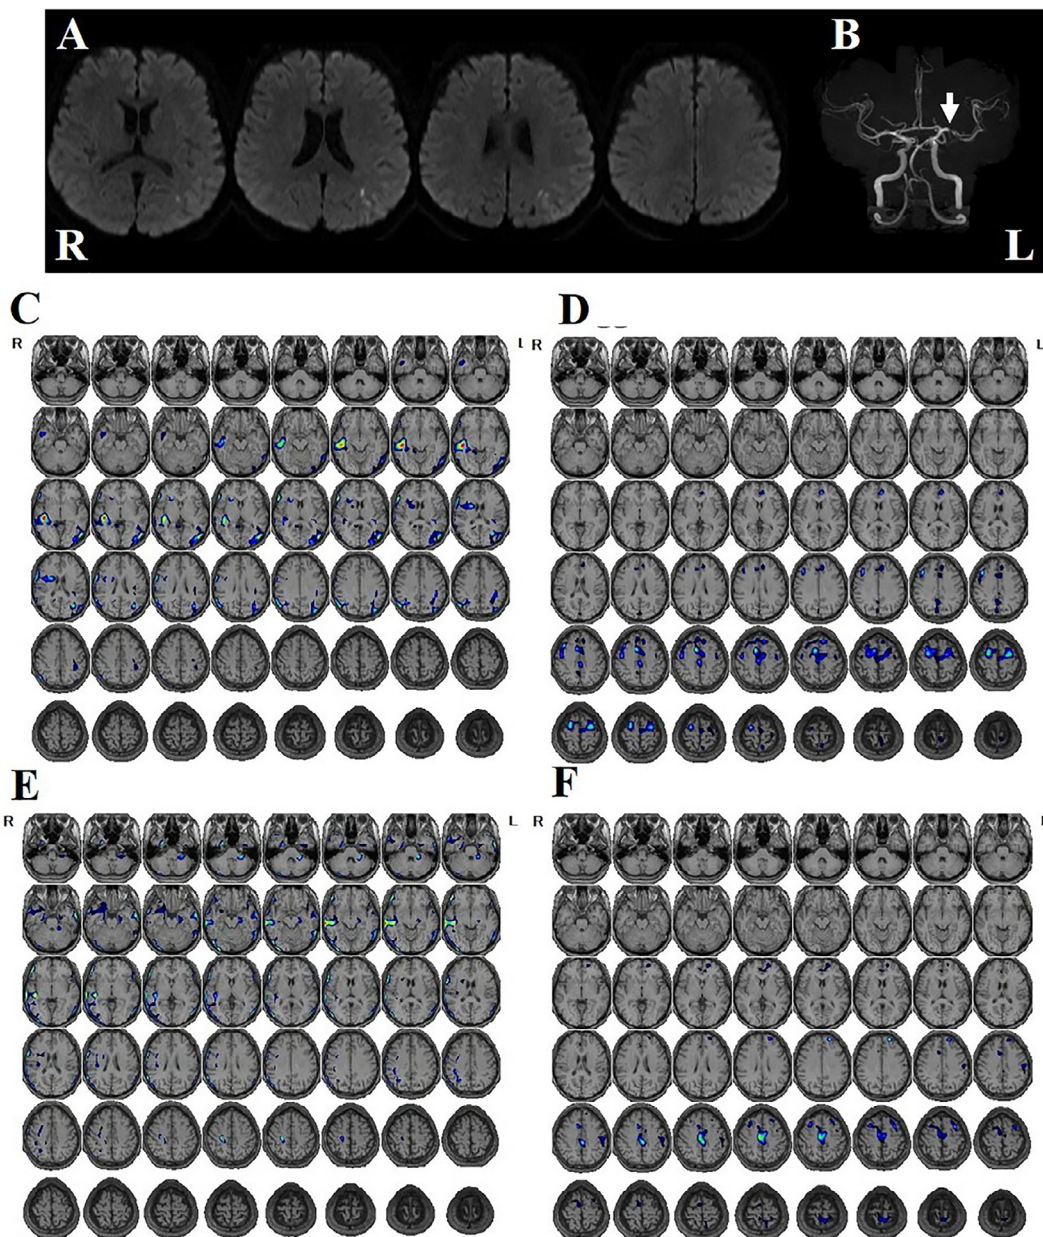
A: Diffusion-weighted magnetic resonance imaging of the patient. A subcortical hyperintense spot is found at the left angular gyrus. B: Magnetic resonance angiography of the intracranial arteries. Stenosis of the left middle cerebral artery was observed (arrow). C–F: Single photon emission computed tomography using *N*-isopropyl-*p*- ^{123}I iodoamphetamine performed on day 5 of hospital stay (C, D) and one month after onset (E, F). Data are analyzed with the Easy Z-score imaging system. Hyperperfusion with Z-score >2 (C, E) and hypoperfusion with Z-score >2 (D, F) are colored.
